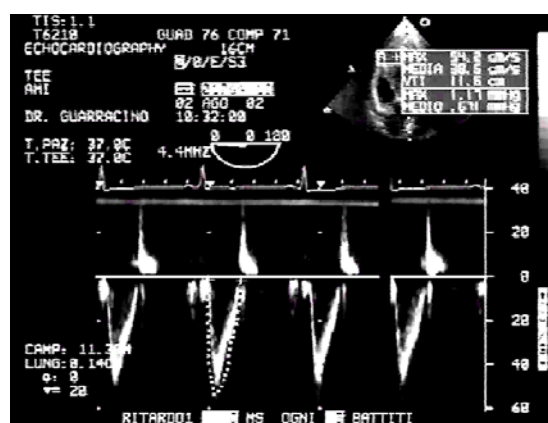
b VTI measurement by Doppler
